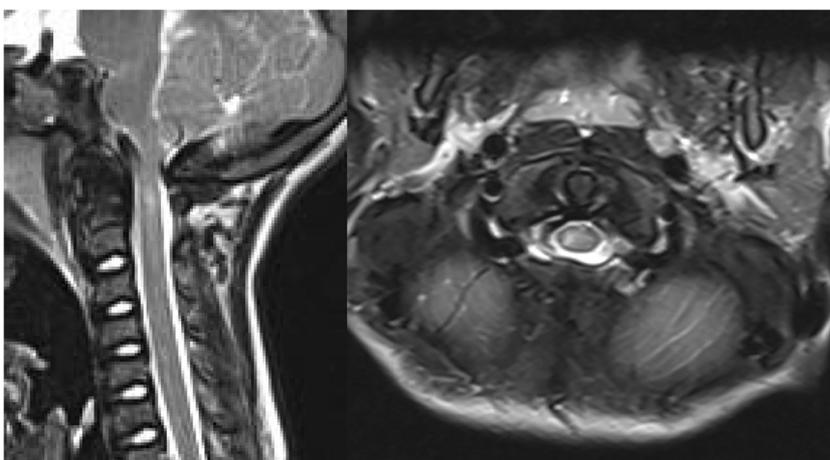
Sagittal and axial MRI images at the 16-month interval showing the complete disappearance of the syringomyelia with marked reduction of the spinal cord edema
